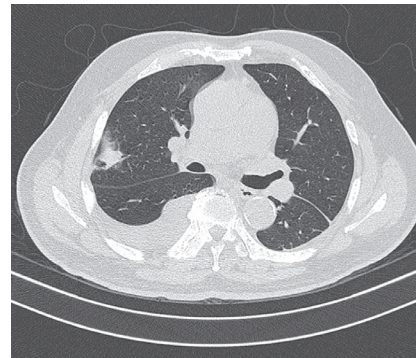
Chest CT scan revealed bilateral pleural effusion and a semi-consolidated lesion in the right upper lobe of the lung, measuring up to 2.6 cm.
